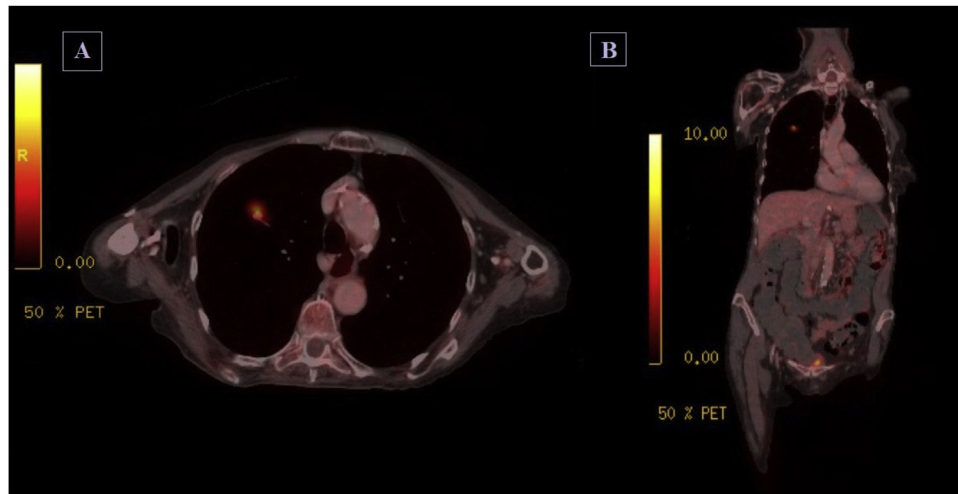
PET-CT images (Positron emission tomography co-registered with computerized tomography). Axial (A) and coronal (B) sections. Hypermetabolic pulmonary nodule in the right upper lobe, suggestive of malignancy.
